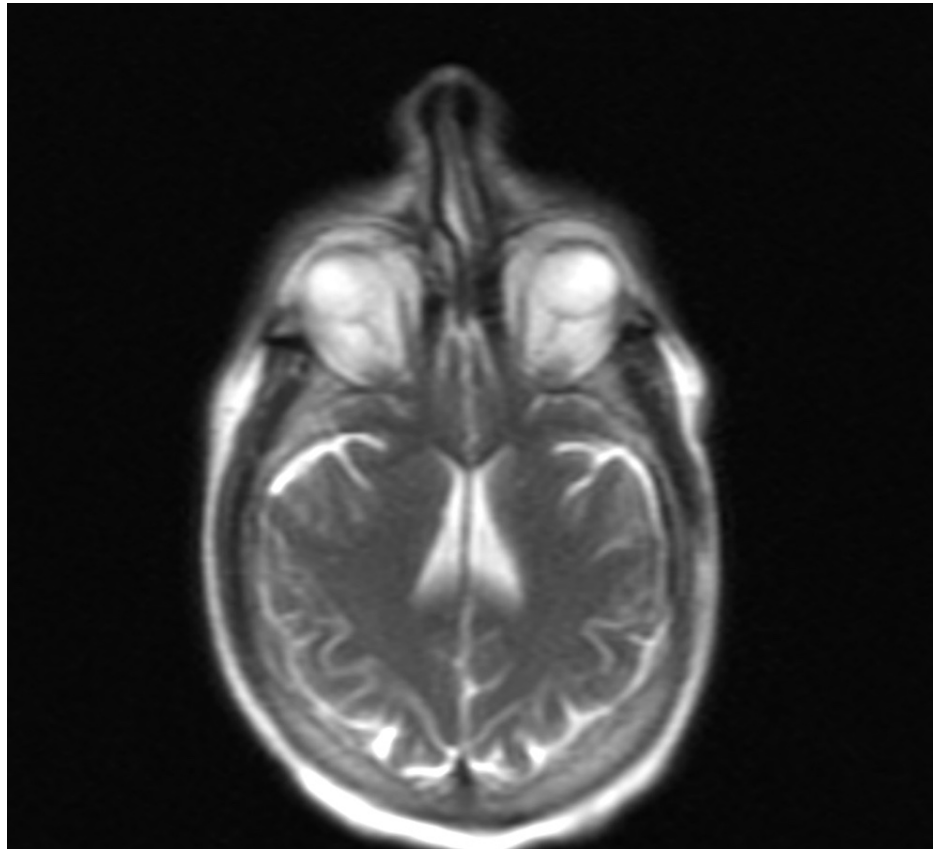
Axial plane of brain MRI with contrast
